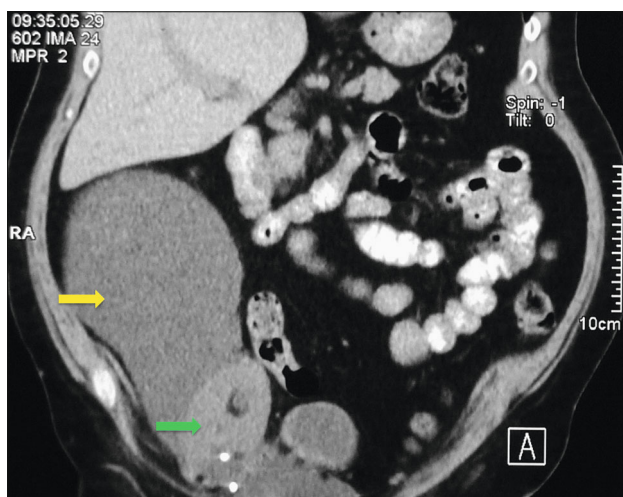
CT picture of large lymphocele (yellow arrow) over the transplanted kidney (green arrow).
